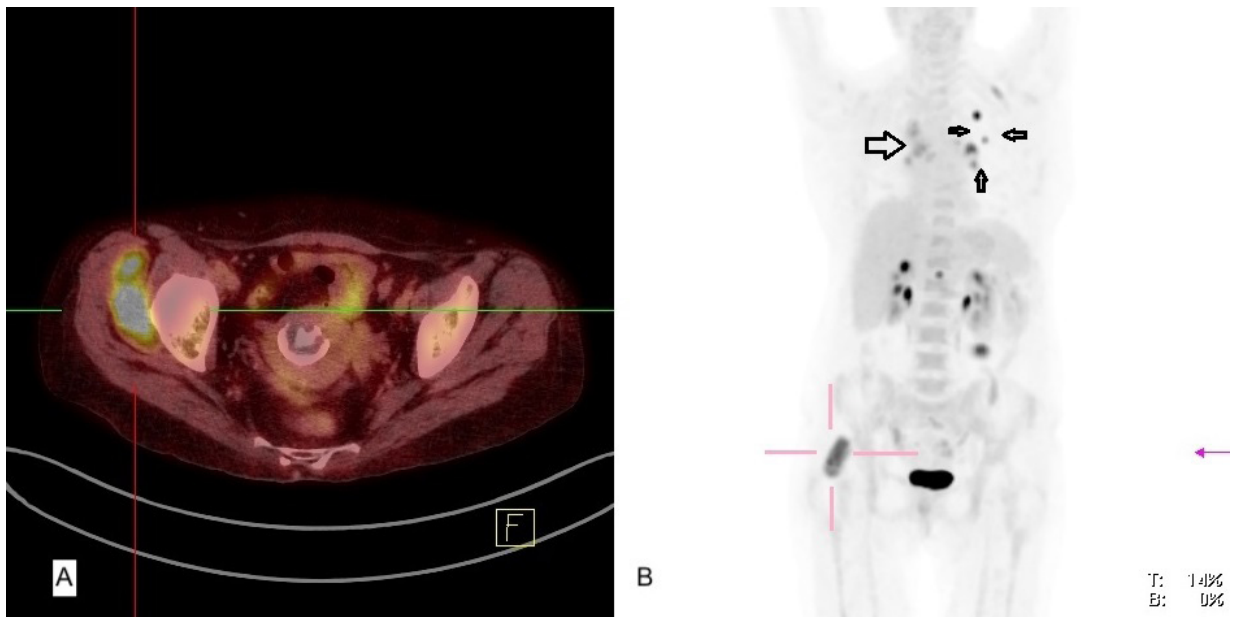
A, Axial: Fused ^{18}F -FDG PET-CT reveals that the previously noted fat-density lesion in the right gluteal region is now FDG-avid (hairline). The lesion in the right gluteal region demonstrated further avidity on the ^{18}F -FDG PET-CT. B, (MIP PET) – Post-treatment ^{18}F -FDG PET at 3 months. The post-treatment ^{18}F -FDG PET-CT shows a partial metabolic response of the previously noted right upper lobe mass (SUVmax: 5.6 g/mL, previously 26.8 g/mL) and the adjoining areas of mediastinal lymphadenopathy (head arrows). New FDG-avid lesions are noted in the left lung and at the T12 vertebra (small arrows).
